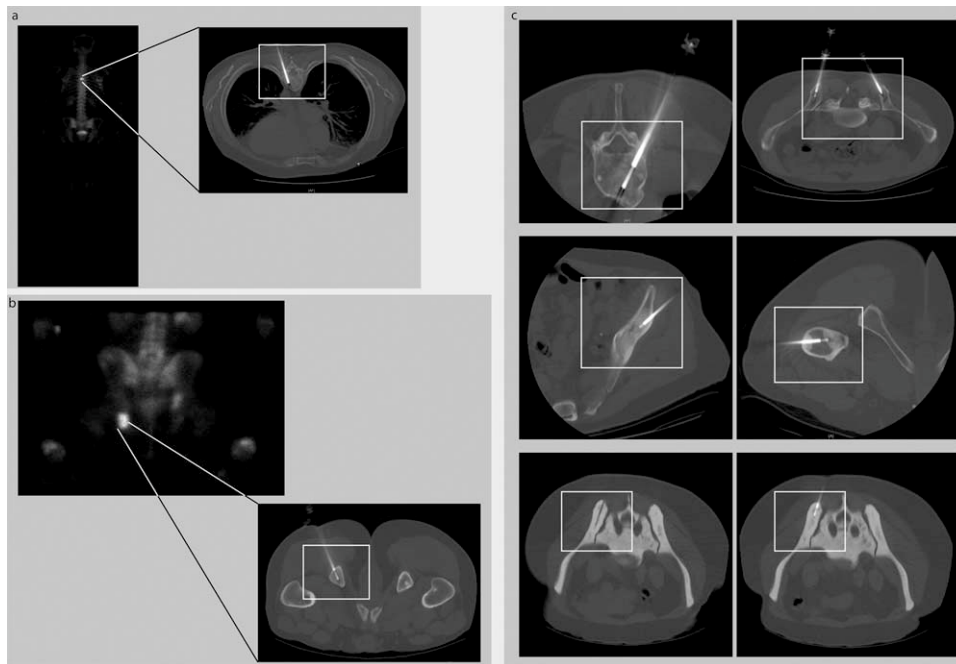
Radiology images of different bone lesions in patients with metastatic prostate cancer who underwent a biopsy using the OnControl drill. (a) T6 vertebral body lesion and (b) lesion of the left ischial tuberosity. (*Left*) Scintigraphic image with clearly visible tracer uptake in both lesions. (*Right*) A corresponding computed tomography (CT) image demonstrating the intralesional biopsy needle. (c) CT images of biopsy procedures in multiple locations in several patients demonstrating safe use of the OnControl drill throughout the bony skeleton. CT-guided biopsy of an extremely dense bone lesion (lower panels: white rectangle, OnControl). The CT images confirm a technically successful biopsy.
